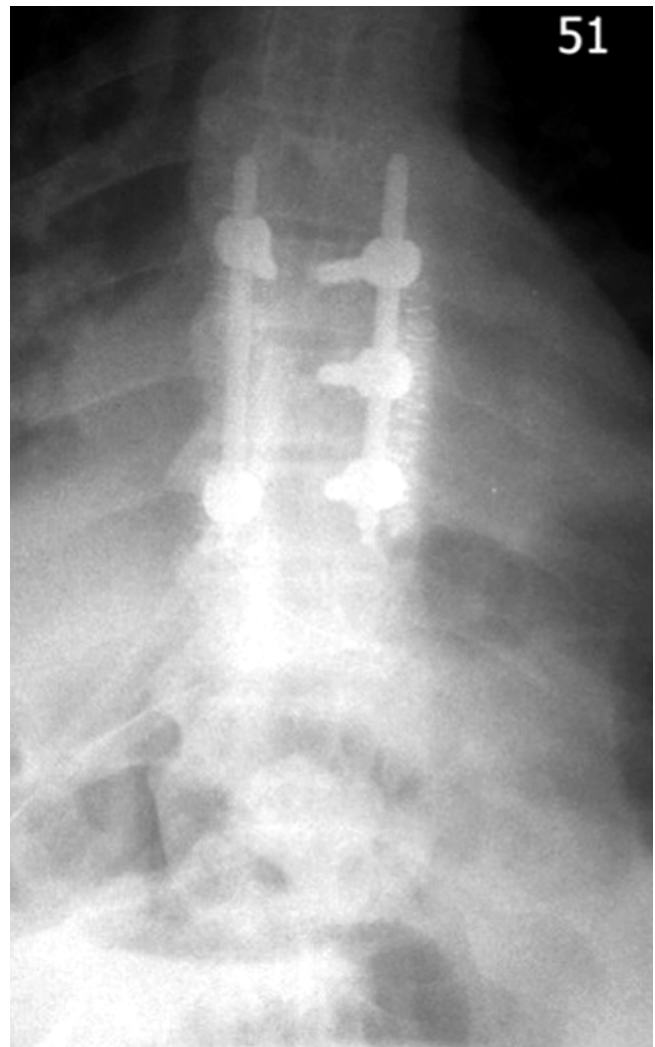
Postoperative AP view radiograph of the patient shown in Figs. 31.7, 31.8, 31.9, 31.10, and 31.11, obtained after he underwent minimally invasive damage control spine surgery
